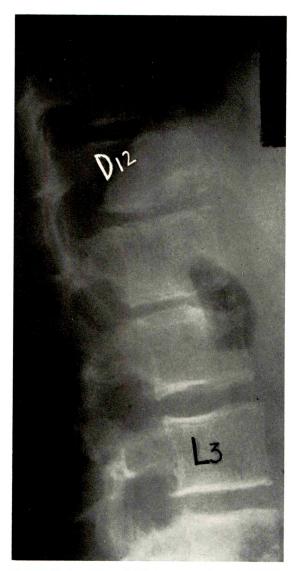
Patient No. 16. There is marginal deformity of the vertebral bodies with associated thinning of intervertebral disk spaces. The roentgenographic appearance resembles that of Scheuermann's disease.
